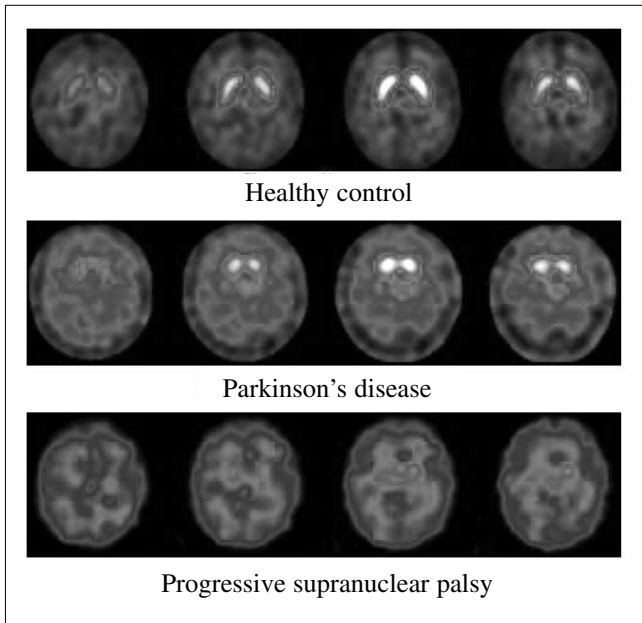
^{123}I -Ioflupane SPECT in a control subject, a PD patient, and a PSP patient
